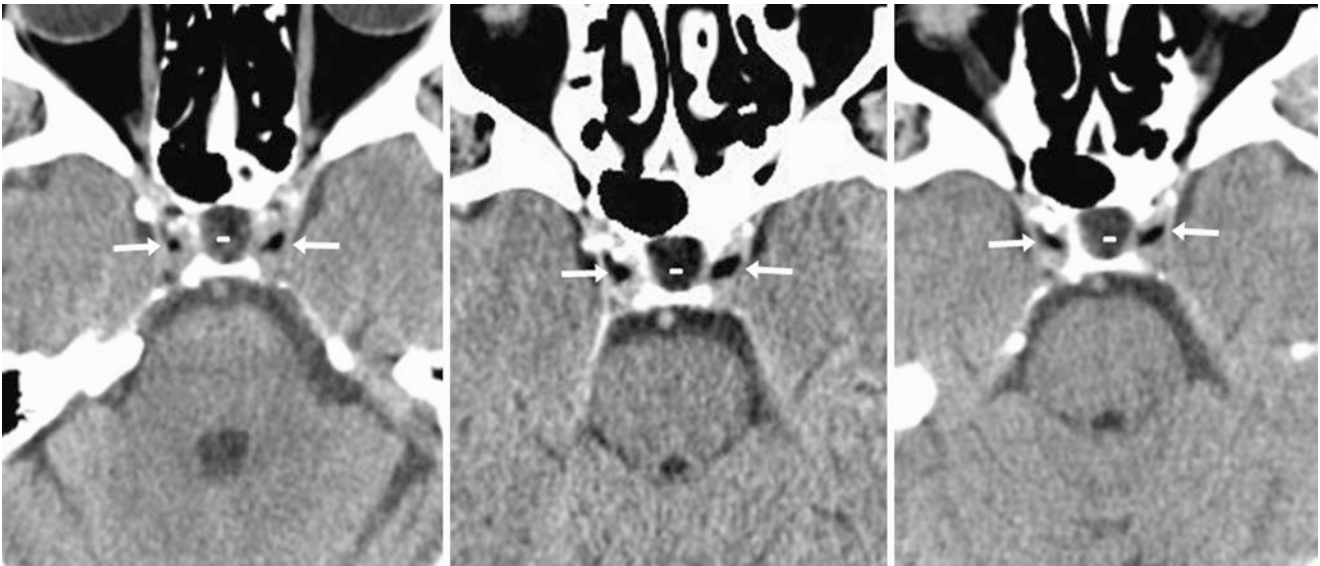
A 55-year-old female with chronic headaches and an otherwise negative head CT scan with normal cavernous sinus fat bilaterally (arrows) on brain windows (left). Note an incidental primary empty
